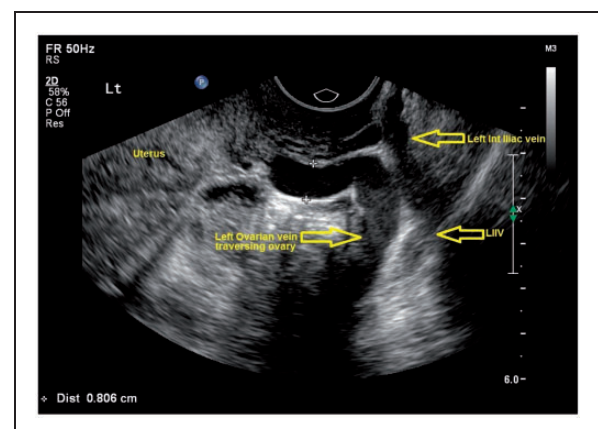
Ultrasound image of a left ovarian vein (LIIV also visible).
